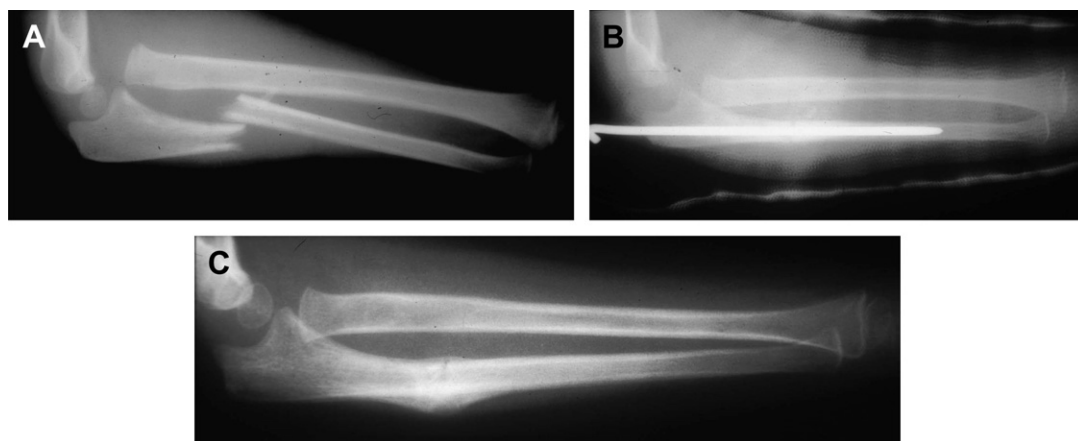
A skeletally immature patient fell off playground equipment and sustained an anterolateral Monteggia injury. (A) Lateral radiograph shows a transverse ulna fracture in bayonet apposition and dislocation of the proximal radioulnar and radiocapitellar joints. (B) Open reduction and intramedullary wire fixation was performed, with ancillary cast immobilization. (C) The fracture healed in good alignment and excellent function was obtained.
